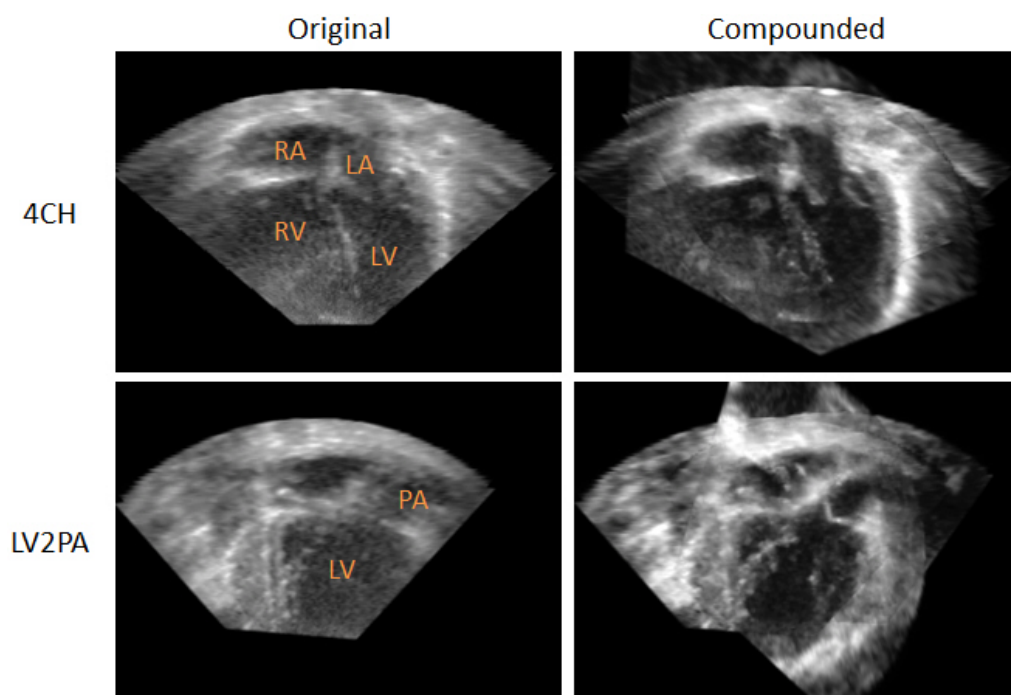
Slices from 3D echo images on TGA2 patient data. Original and compounded images are presented in the following view angles: 4CH (apical four chamber) and LV2PA (left ventricle to pulmonary artery). My compounded images shows less noise, more contrast and with TGA features well presented in single volume. (LV = left ventricle; LA = left atrium; RV = right ventricle; RA = right atrium; PA = pulmonary artery)
